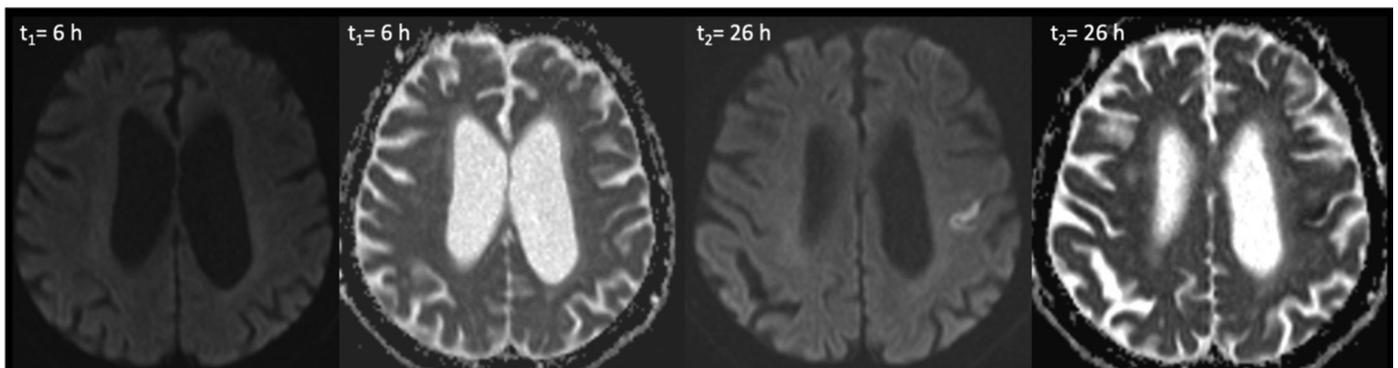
Isolated cortical syndrome: A 81 year-old-female with hypertension and atrial fibrillation was admitted with acute onset central facial paresis and dysarthria. (Admission NIHSS: 4; 24th hour NIHSS: 4) While DWI performed at the sixth hour after the onset of the symptom did not document the lesion, DWI performed twenty hours later showed a small-sized cortical infarction in the posterior frontal lobe. The lesion involves the facial area of the homongulus in accordance with the clinic deficit
